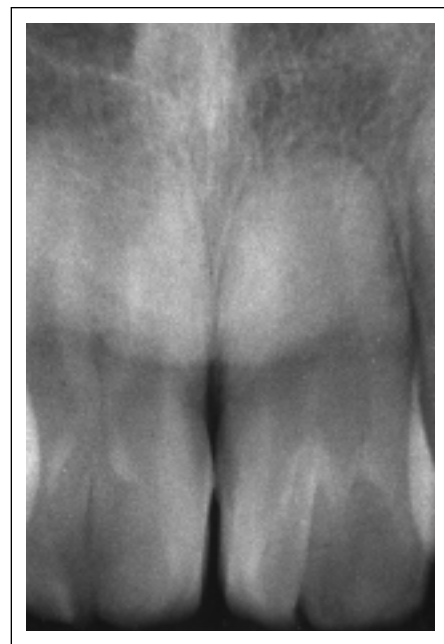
Periapical roentgenograms of the germinated and fused maxillary central incisors.
